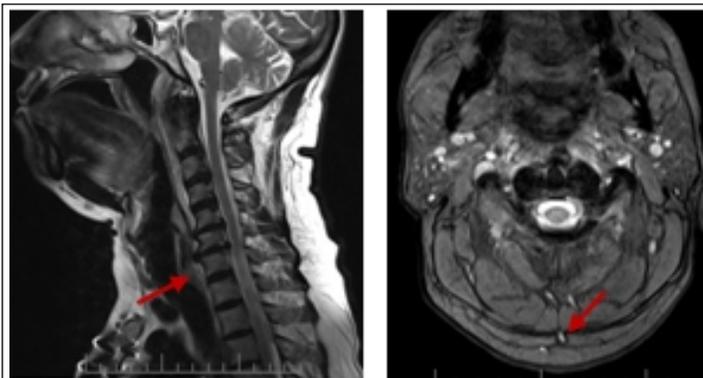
Magnetic resonance imaging T2 sagittal and T2 axial images of case 4. Arrow denotes inflammatory effusion at the level of C1-C2 vertebrae and the calcific deposits.
